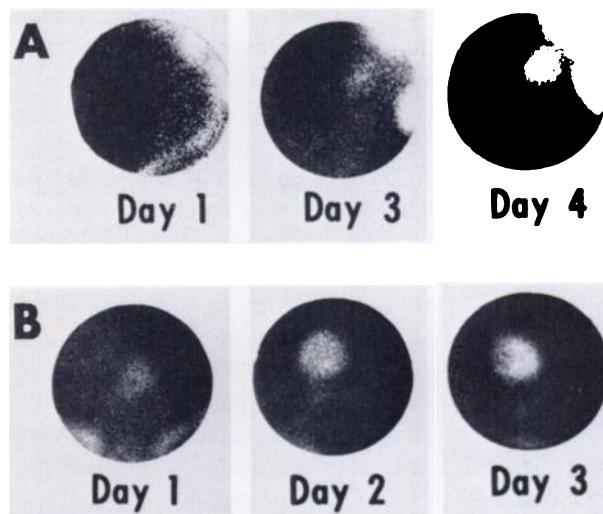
Serial scintigraphs of two hyperacute rejecting renal allografts with ^{99m}Tc -sulfur colloid. Initial transplant visualization is present as early as 1 day after grafting. (Series A) transplantation in iliac fossa, (B) transplantation in carotid area.
